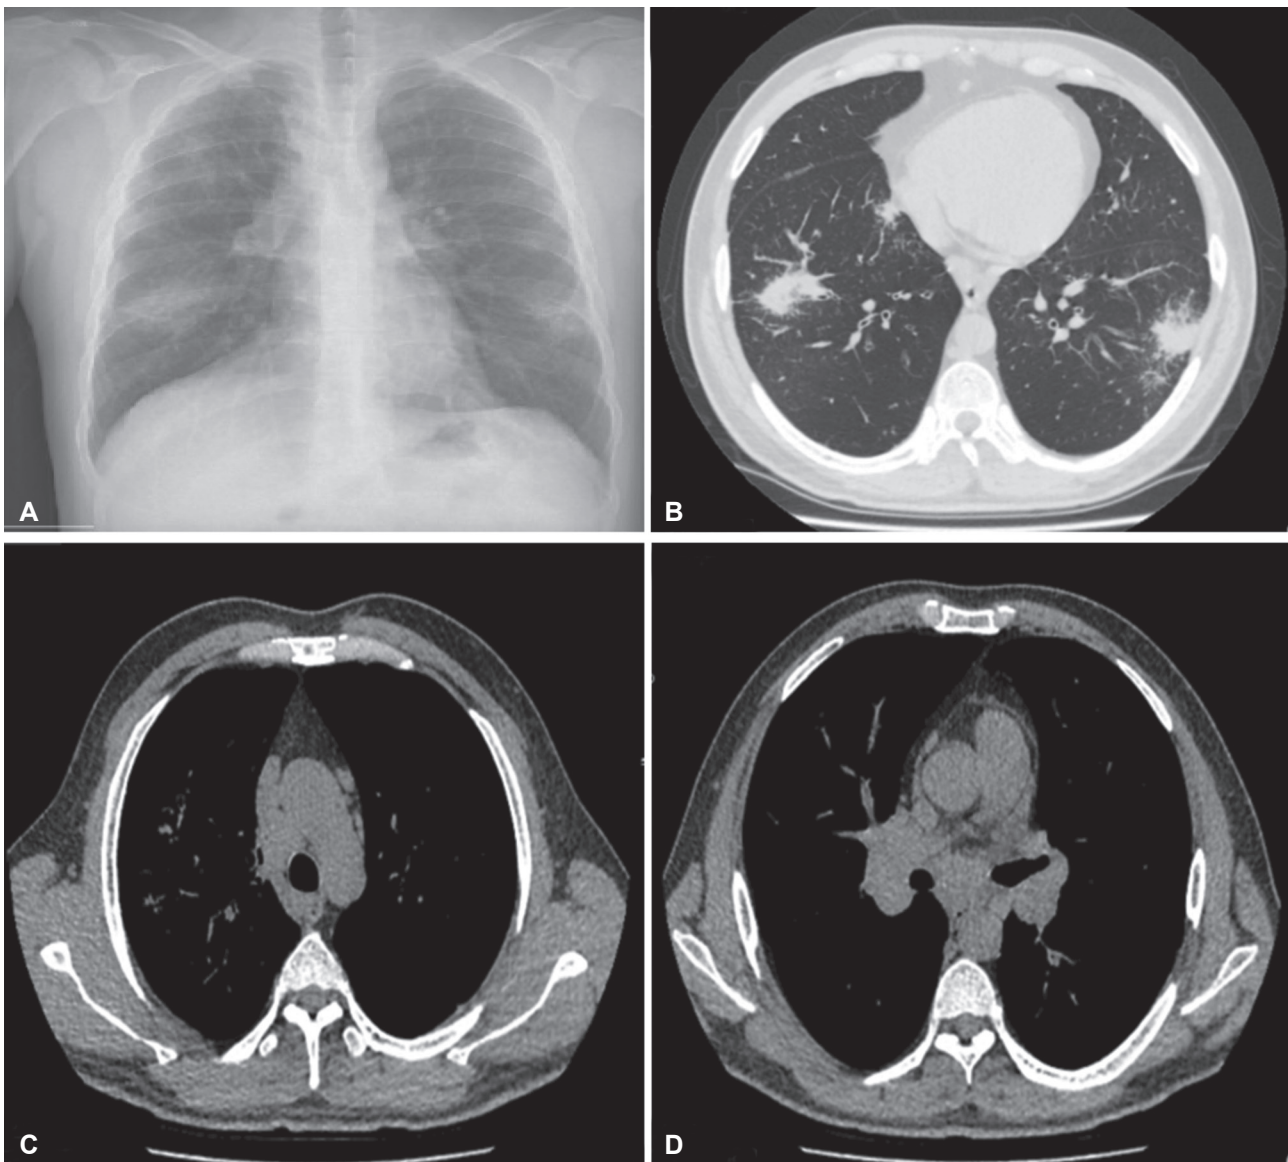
A) Posteroanterior Chest X-ray. Peripheral reticulonodular densitic areas were observed in bilateral lower zones, B-C-D) Non-contrast Thorax Computed Tomography (B: peripheral consolidation areas in bilateral lower lobes, C: right inferior paratracheal lymph nodes, and D: subcarinal lymph nodes).
